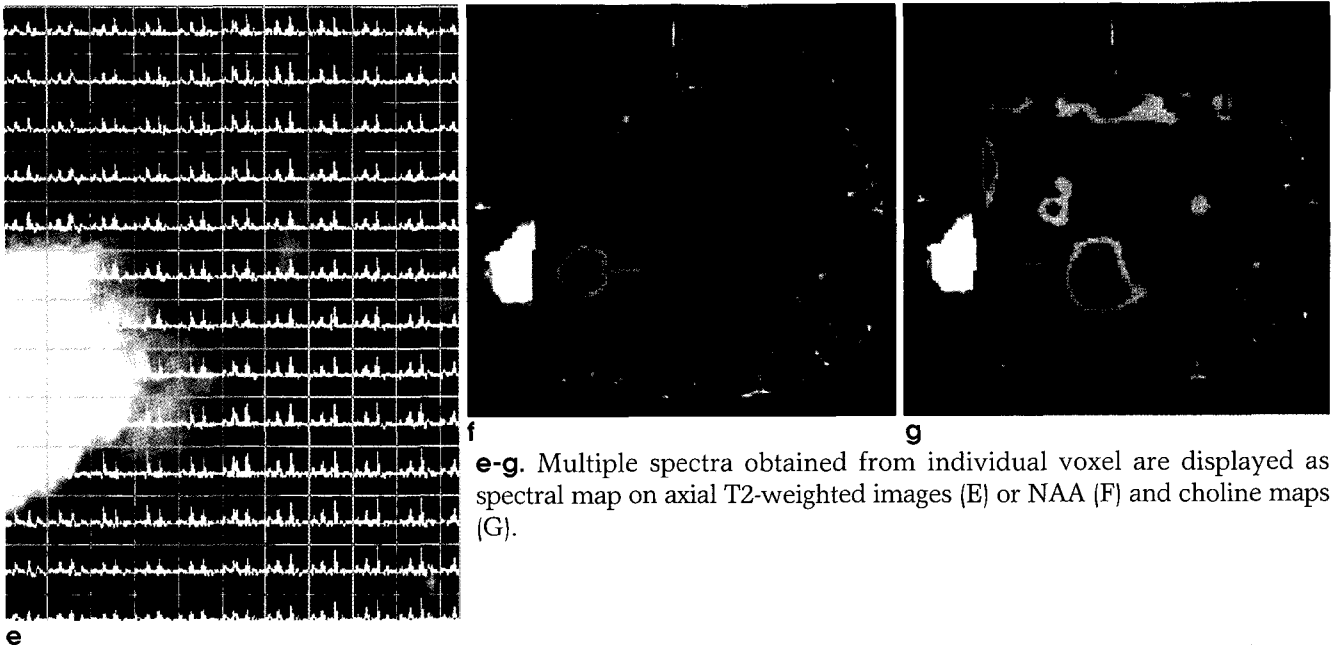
Localization scheme of hybrid 2D proton SI in 13-year-old boy with recurrent glioblastoma multiforme. a. Gadolinium-enhanced T1-weighted spin-echo image (TR/TE=665/14) demonstrates enhancing recurrent tumor (arrows) at the periphery of the cystic lesion in the right parietal region. b. To prevent contamination from subcutaneous fat, hybrid volume of interest (VOI) is selected within the field of view (FOV) on axial T2-weighted image. The hybrid VOI is $7.5 \text{ cm} \times 7.5 \text{ cm}$ along the x-, and y-directions. c, and d. Hybrid VOI along z-direction is 1.5 cm on coronal (C) and sagittal (D) localization images.
